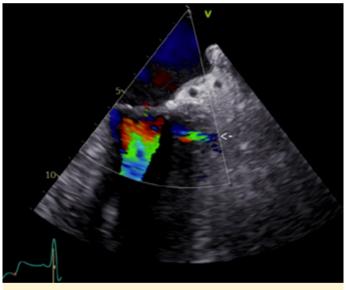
Transesophageal echocardiography showing the left ventricular pseudoaneurysm in the inferolateral segment and color Doppler flow.
